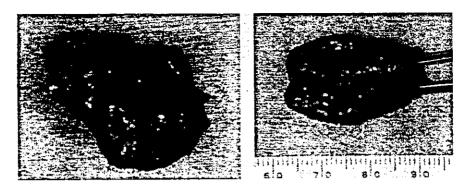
Macroscopic findings of the resected part of the left adrenal gland. The resected part shows multiple nodules, about I mm in diameter, in addition to the mass revealed by CT.
